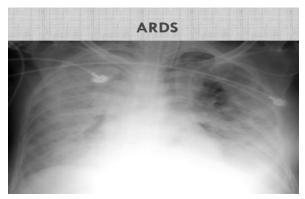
Fig no: 5 Picture of X-ray with ARDS
